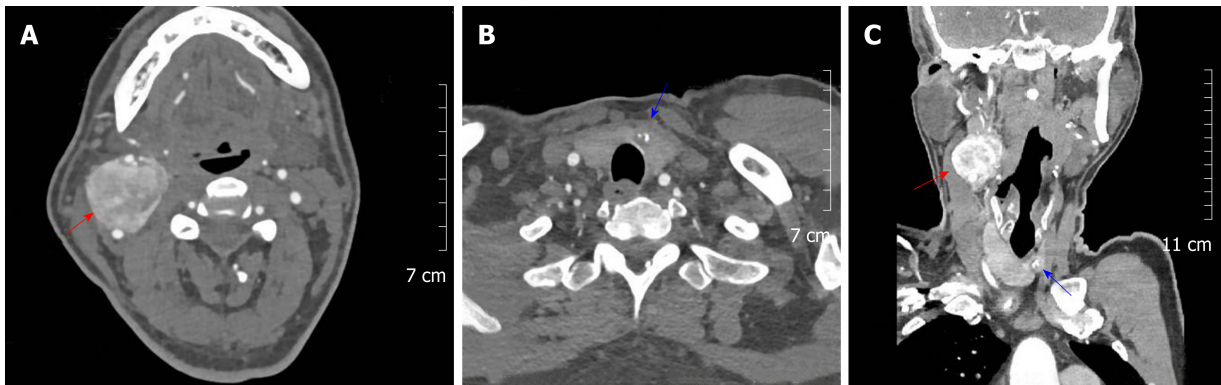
Preoperative images of the tumor. A: The paraganglioma located in the carotid artery bifurcation (red arrow); B: A low-density nodule of the thyroid isthmus with a high-density calcification can be seen (blue arrow); C: Enhanced computed tomography showing coexistence of paraganglioma (red arrow) and thyroid carcinoma (blue arrow).
